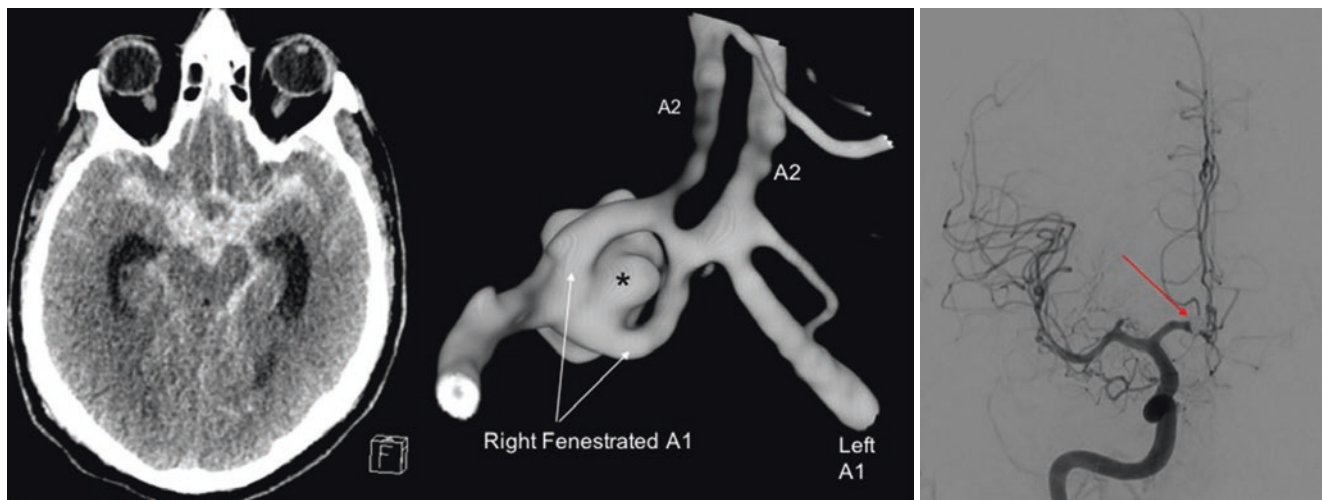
Clinical case of aneurysm located on a fenestrated A1 segment. The figure shows the case of 56-year-old man, who experienced unusual headache without neurological deficits associated. The CT scan showed
